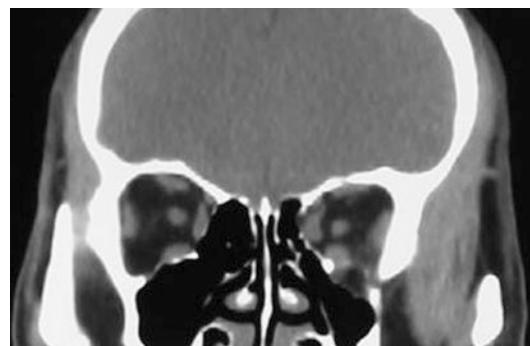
Preoperative CT scan showed that the left medial orbital wall and infraorbital wall were fractured, the medial rectus muscle and the inferior rectus muscle were displaced, and the orbital tissue herniated into the maxillary sinus
